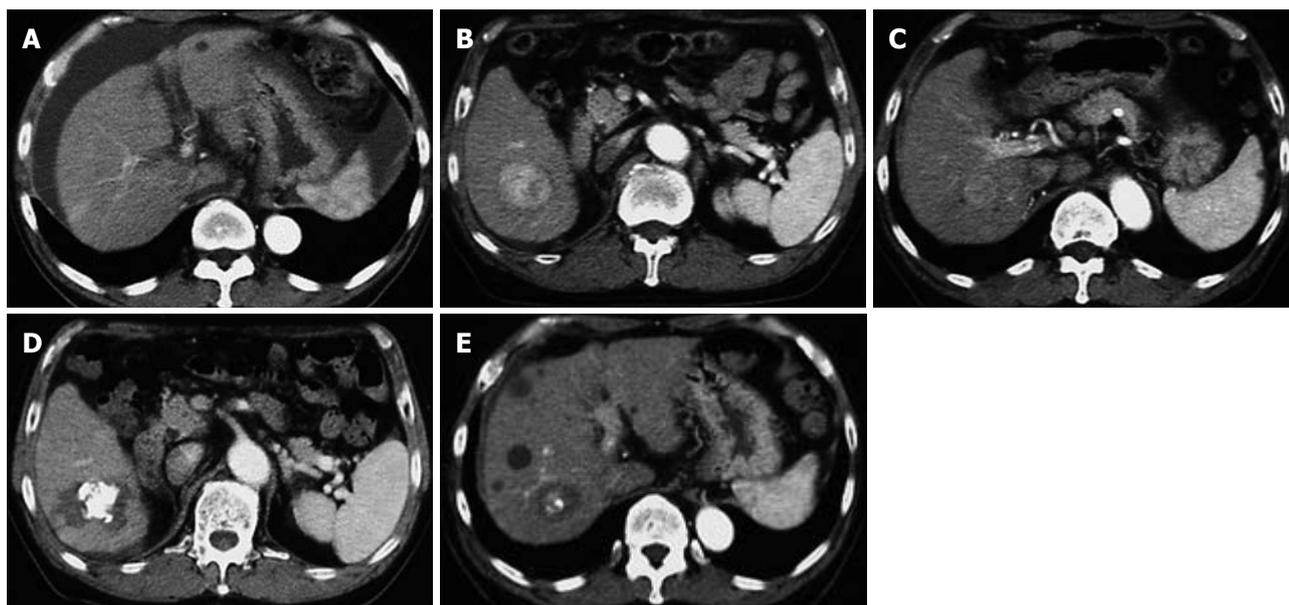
Computed tomography in our patient. It shows a cirrhotic pattern of the liver and massive ascites at first admission (A); Dynamic computed tomography revealed two hepatocellular carcinomas, 4.5 cm (B) and 2.5 cm (C) in diameter, in the right lobe; These two lesions were treated by transcatheter arterial chemoembolization and radiofrequency ablation (D, E).
